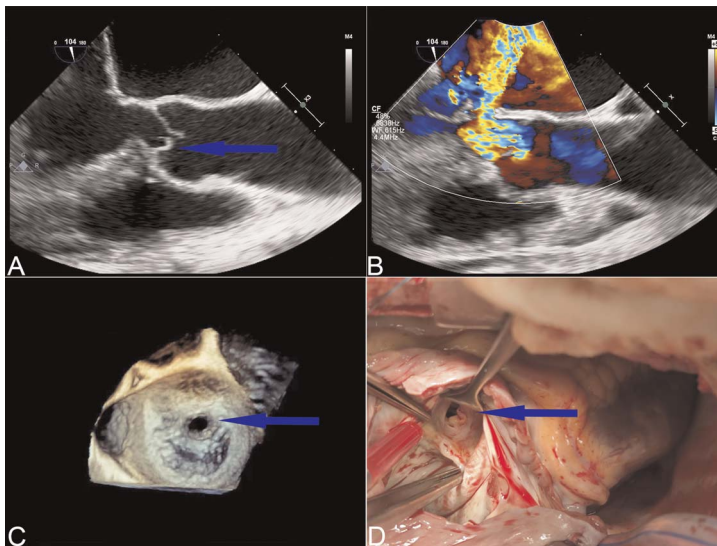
Transesophageal echocardiography images. (A) The prolapse of the aortic right coronary valve. (B) Aortic valve regurgitation beam in the left ventricular outflow tract impinged exactly on the mitral valve perforation area. (C) Mitral valve anterior leaflet root perforation. (D) Perforation in the anterior mitral leaflet during the operation.
